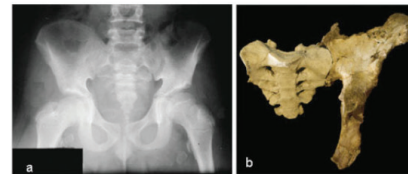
(a) Radiograph of a 22-year-old man with Laron Syndrome (modified from Kornreich *et al.*, 2008); (b) left ox coxae of LB1 articulated with a cast of the sacrum of AL 288-1 (*Australopithecus afarensis*); (c) female pelvis; (d) male pelvis; (e) australopithecine pelvis (c-e adapted from Lovejoy, 2005). The similarity between b and e is noteworthy. Modified from Falk *et al.*, 2009.
